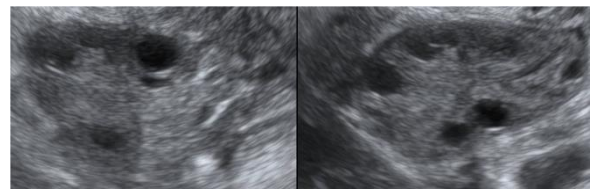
Ultrasound images of the left ovary (left) and right ovary (right), taken 4 months after ovarian vein thrombosis and showing normalization of the ovarian size and morphology.
